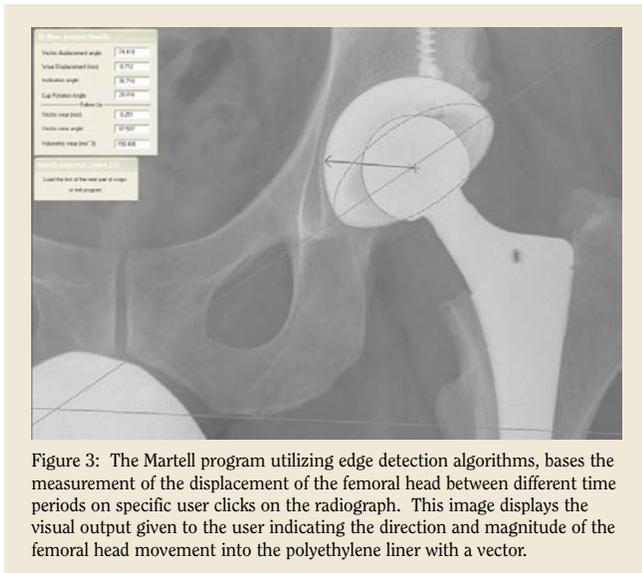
The Martell program utilizing edge detection algorithms, bases the measurement of the displacement of the femoral head between different time periods on specific user clicks on the radiograph. This image displays the visual output given to the user indicating the direction and magnitude of the femoral head movement into the polyethylene liner with a vector.
